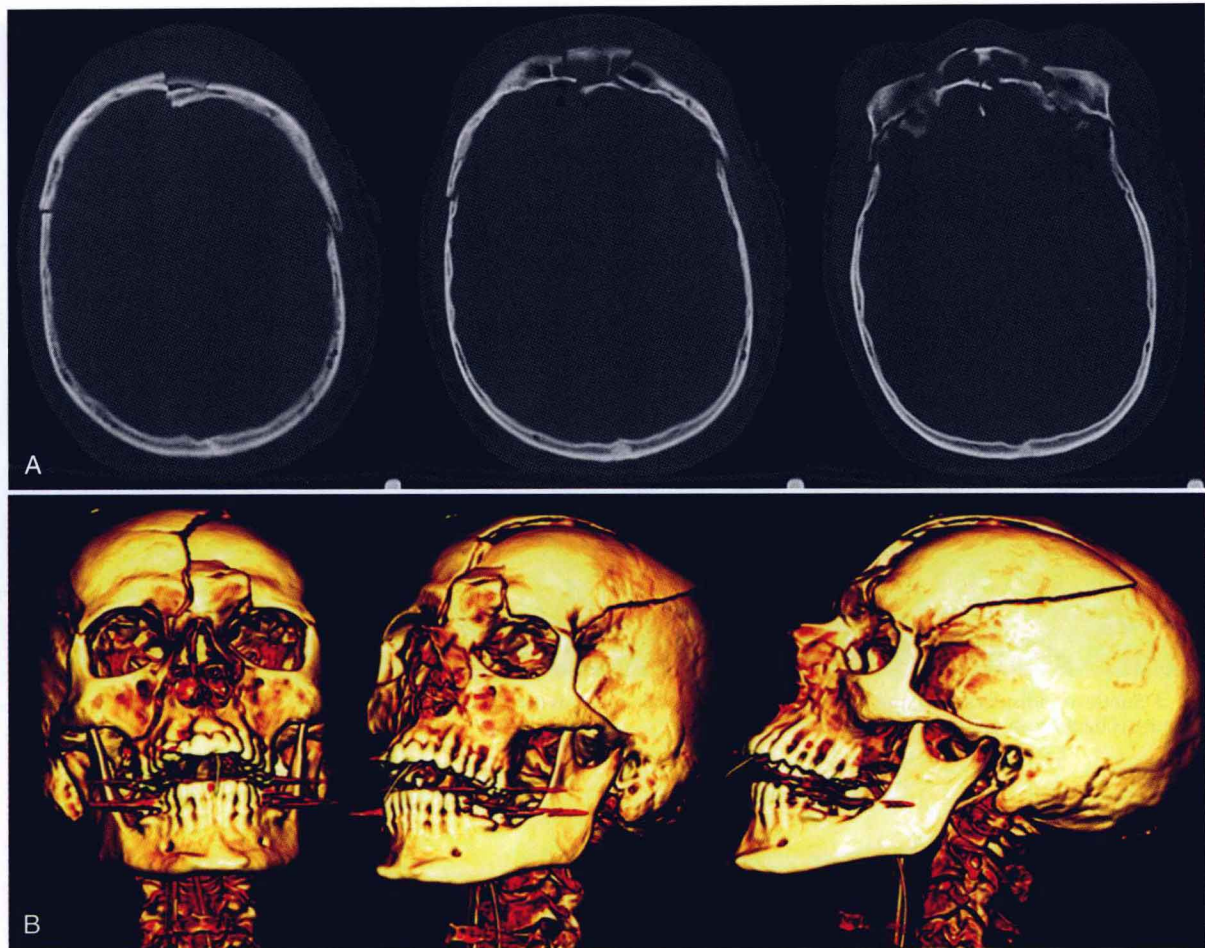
Noncontrast maxillofacial multidetector computed tomography of a 45-year-old man who presented with a history of a fall from a 30-foot ladder. A: Axial computed tomographic slices showing fracture through the frontal eminence and parietal bone. B: The extent of fracture from the frontal eminence to the left parietal bone and the relationship between the various fracture fragments are much better appreciated on these three-dimensional surface-rendered views.
